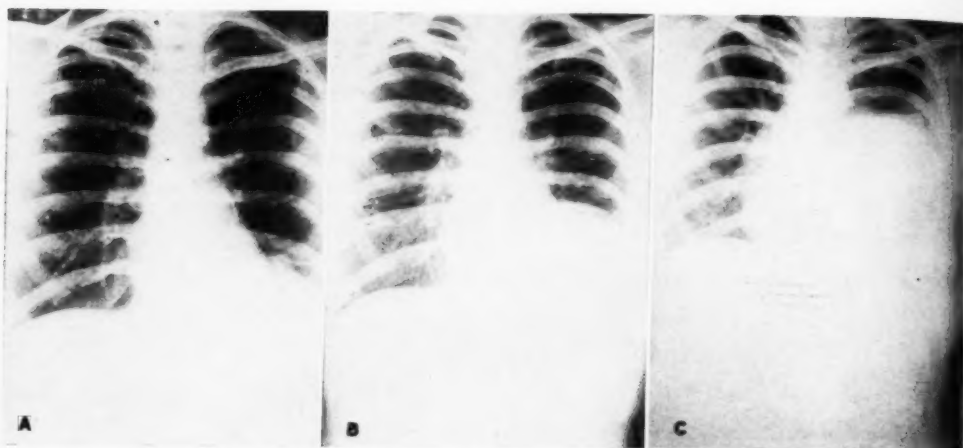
Roentgenograms of chest showing the rapid growth of the metastatic tumor. A. Nov. 8, 1943. B. Jan. 15, 1944. C. March 9, 1944, six years after removal of the original lesion in the arm.
